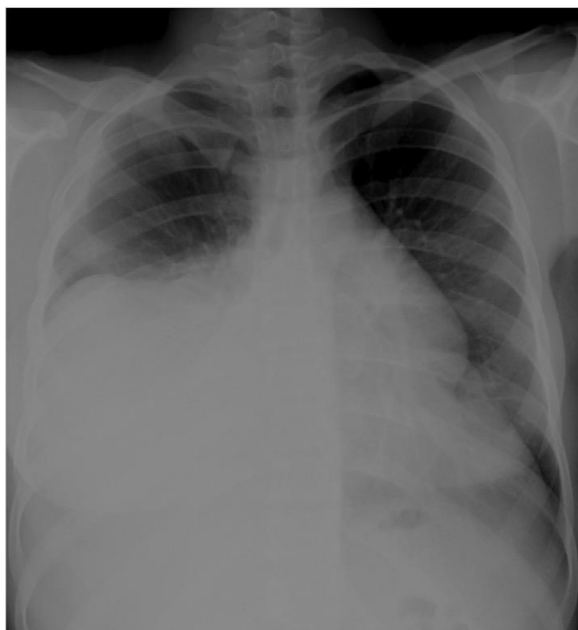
Posterioranterior chest x-ray where right pleural effusion is seen.
